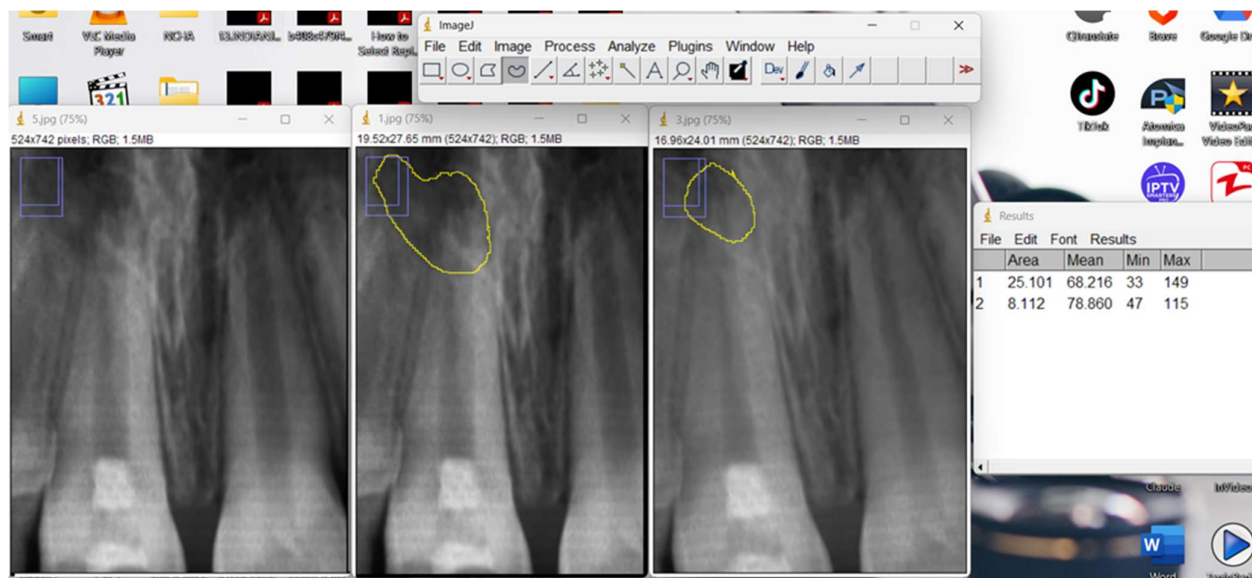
Digital measurements of the area of the periapical lesion using image J software.
